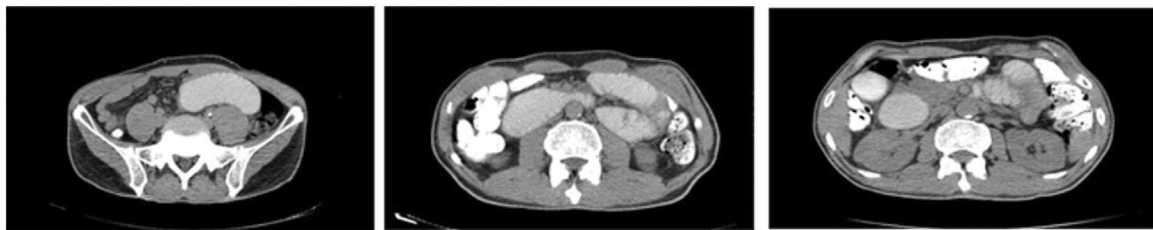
CT abdominal scan after administration of Gastrografin revealed an increase of air-fluid levels.
